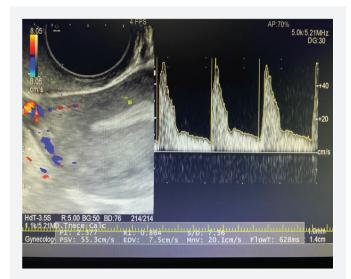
Transvaginal Doppler ultrasound examination of uterine artery is depicted. The uterine artery loop is located in a paracervical section, and at least three identical waveforms are recorded
